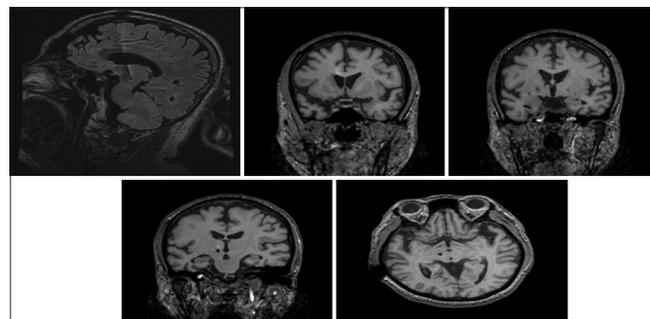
Subthalamic nucleus (STN) trajectory. T1 magnetic resonance imaging showing trajectory of the right STN electrode. Top left – sagittal view of electrode at target, top middle – coronal view with electrode entering right lateral ventricle, top right – electrode exiting ventricle, bottom middle – axial view of electrode at target.
